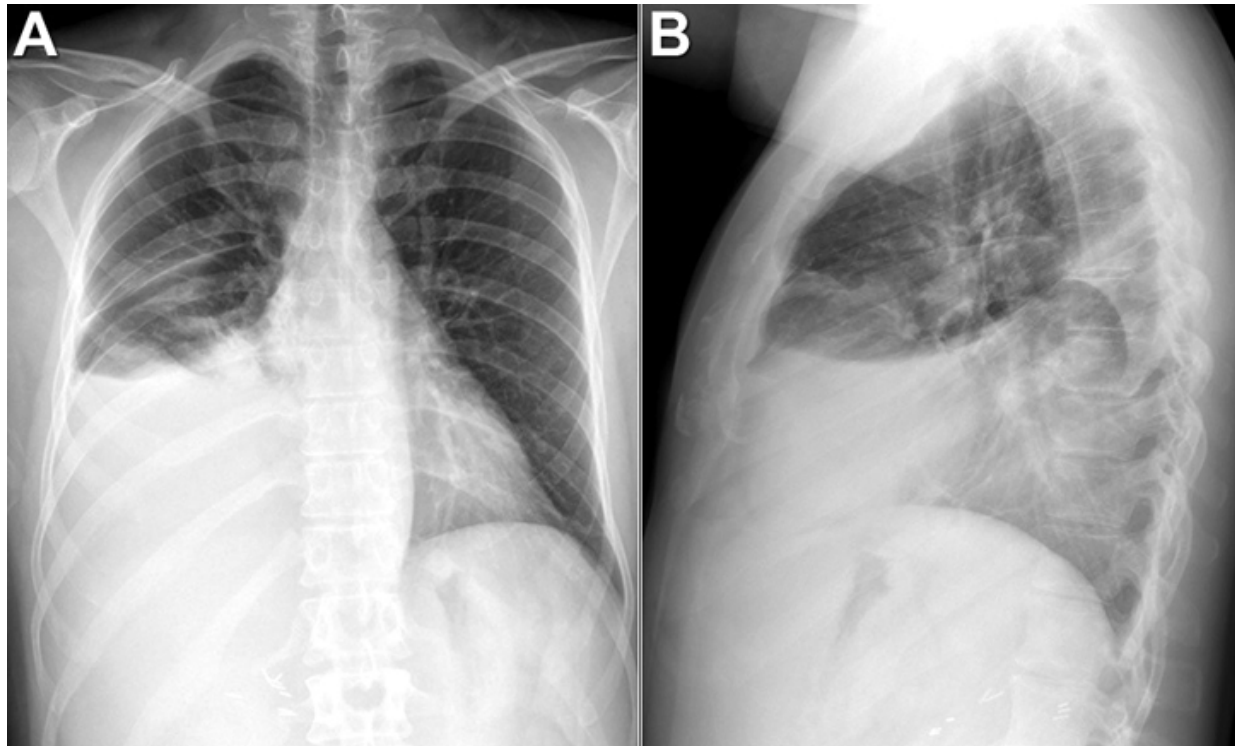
Frontal and lateral chest radiography performed several days following the right-sided percutaneous microwave ablation procedure.
